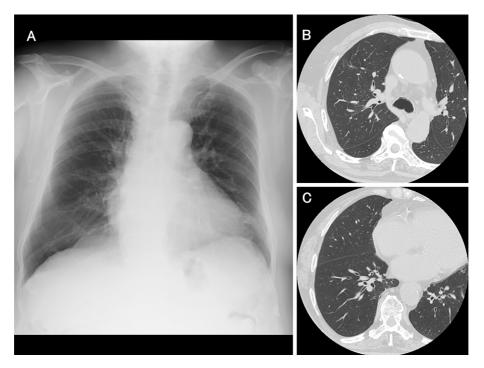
Chest radiograph taken at initial presentation shows no abnormality (A). Computed tomography of the chest shows thickening of the bronchial wall without emphysema (B, C).
